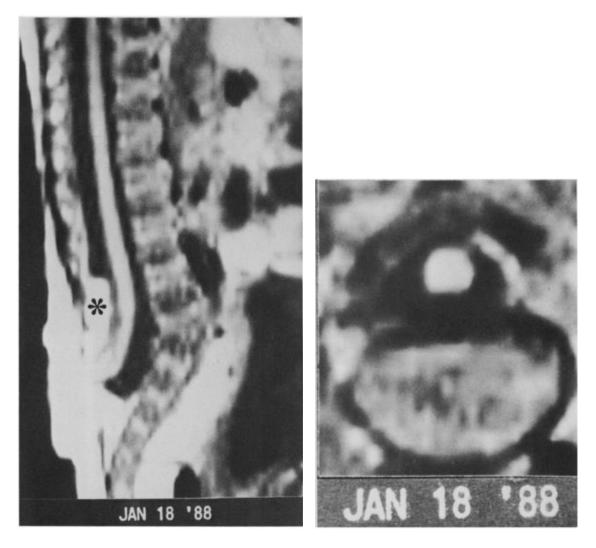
shows an MRI scan taken when the baby was 9 days old. It's a type of MRI called T1-weighted, which helps doctors see certain details. The image on the left is a side view (sagittal), and the one on the right is a front view (coronal). In the scan, you can see that the end of the spinal cord is lower than usual (indicated by ''lowered conus''), and there's a fatty lump inside the spine in the lower back area (marked by an asterisk), which is called an intraspinal lipoma.
